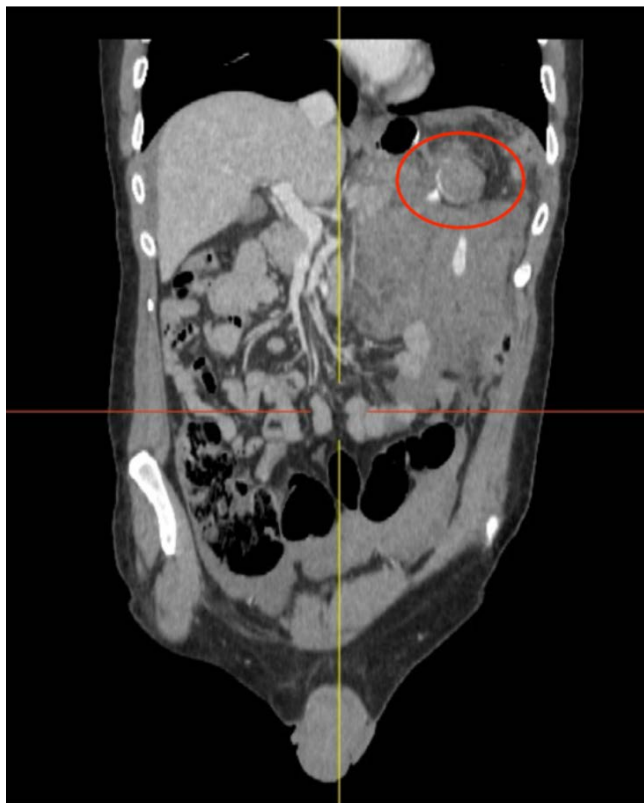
Computed Tomography (CT): sagittal view of the pseudo-aneurysm with abdominal blood effusion.
